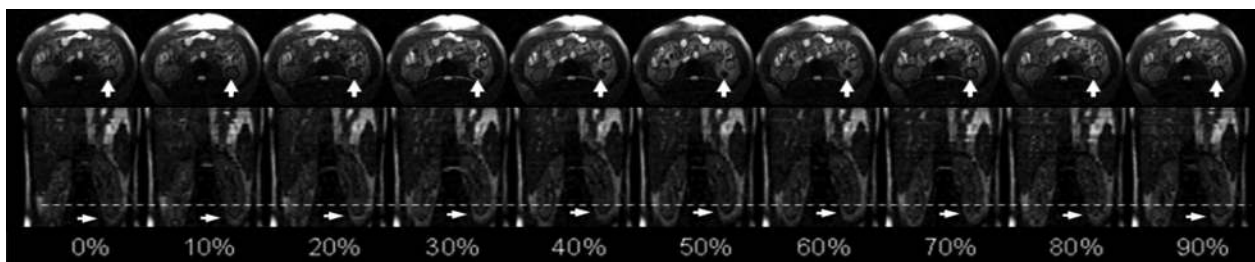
Representative 4D-MRI images of Subject #1. Dash lines are drawn to facilitate the visualization of the respiratory motion. Arrows indicate the tracking point (inferior portion of the left kidney) that was selected to generate the motion trajectory.
